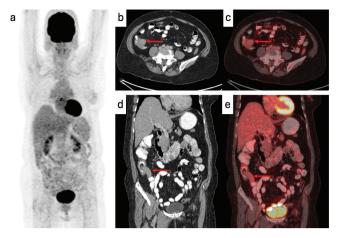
This is the maximum intensity projection image a. of F-18 FDG PET/CECT of the patient with invasive lobular carcinoma of right breast. Axial CECT, PET/CECT images b, c. &; coronal CECT, PET/CECT d, e. images show mildly FDG avid non-enhancing irregular circumferential wall thickening involving the terminal ileum and ileocecum with partial luminal narrowing (red solid arrow)
